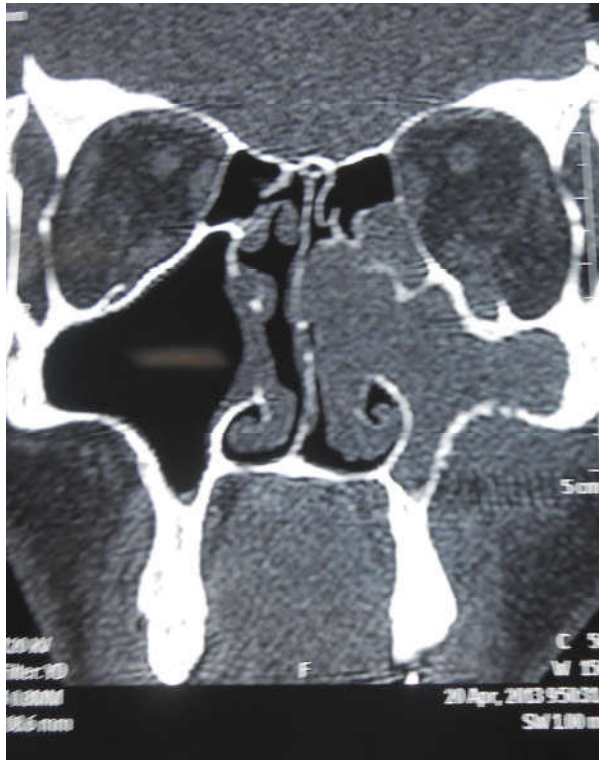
CT scan PNS showing the mass left maxillary and ethmoidal sinus
